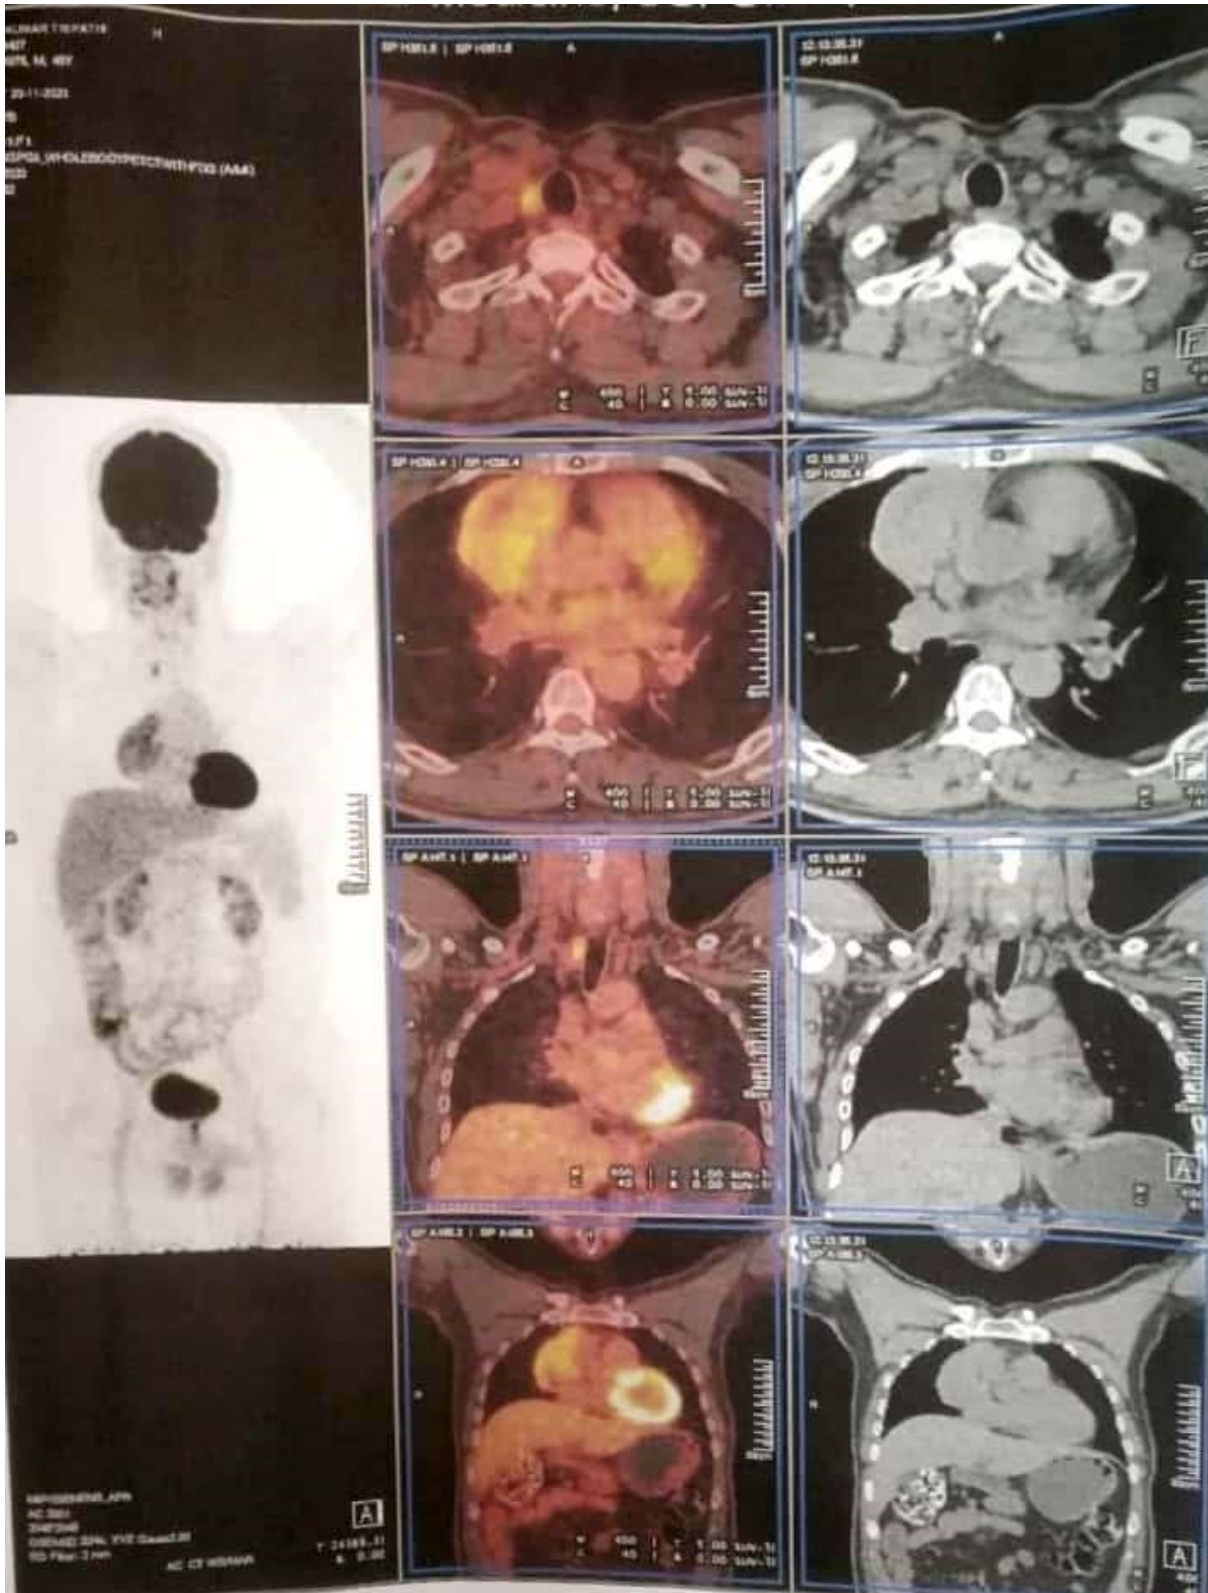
Whole body CT scan
